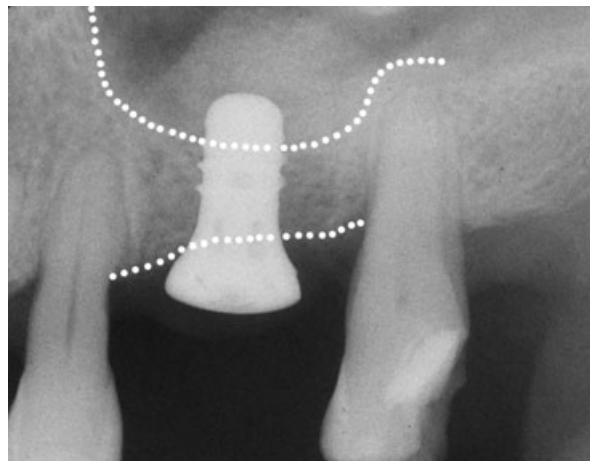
A radiograph, taken after implant placement, showing a dome-shape configuration of the graft. In this instance, 0.25 g of grafting material (xenograft) was used to elevate the sinus membrane (the dotted lines represent the outlines of the residual bone).
